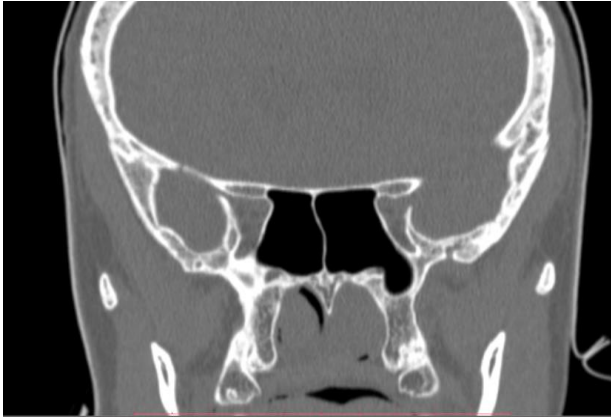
Coronal reconstructed CT of the paranasal sinus showing a near-complete obliteration of the nasal cavities.
